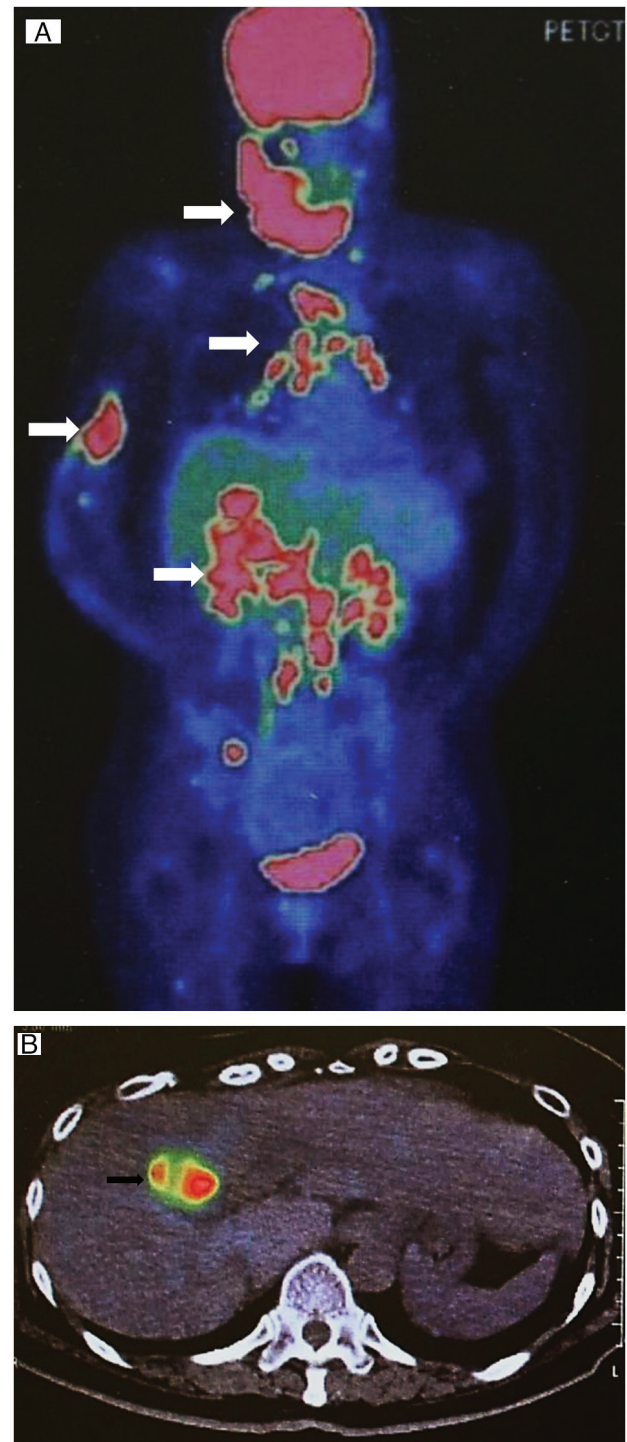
PET-CT imaging. A) Coronal fused image of ^{18}F -FDG PET/CT showing extensive hepatic, lung, humerus (right side) and mandibular (right side) metastasis (white arrows); B) fused images of ^{18}F -fluoro-2-deoxy-D-glucose PET/CT showing the primary tumor in the fundus and body of the gallbladder (black arrow). PET/CT, positron emission tomography-computed tomography.
